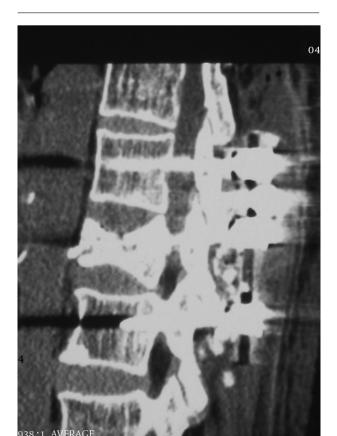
A, Postoperative axial view of L1 vertebra demonstrating epidural/intradural leakage of CP and a medially misplaced L1 screw on the right; CP seems to emerge from the medial wall of the right L1-pedicle; B, Sagittal CT-scan reconstruction image showing both intradural and epidural CP leakages.
